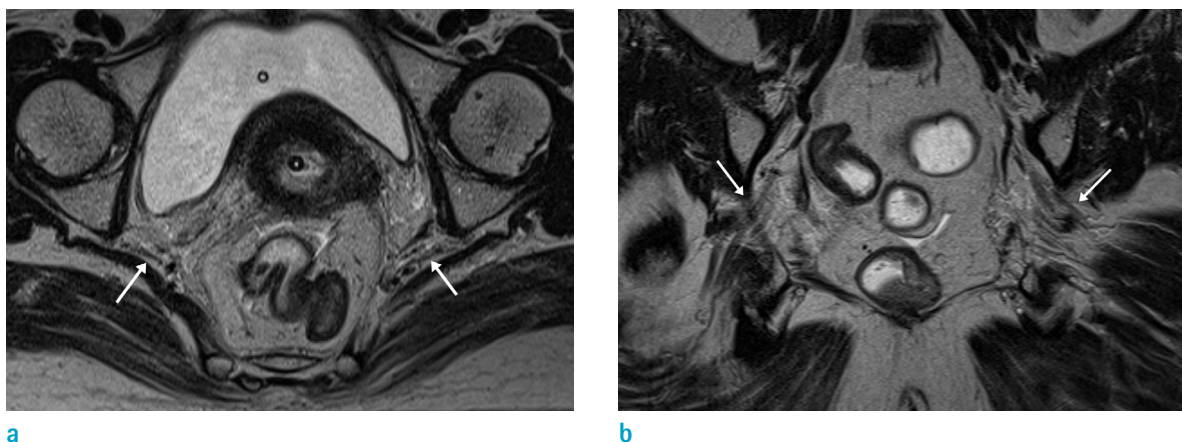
The MR feature of the LSP before CCRT. The pre-CCRT pelvic protocol MRI (a, axial T2WI; b, oblique coronal T2WI perpendicular to the cervix) reveal normal bilateral LSP at both of the sciatic foramen (arrows). Newly defined diffuse thickening of the bilateral LSP after CCRT completion can be heightened by comparing the images acquired before and after the CCRT. LSP = lumbosacral plexus
